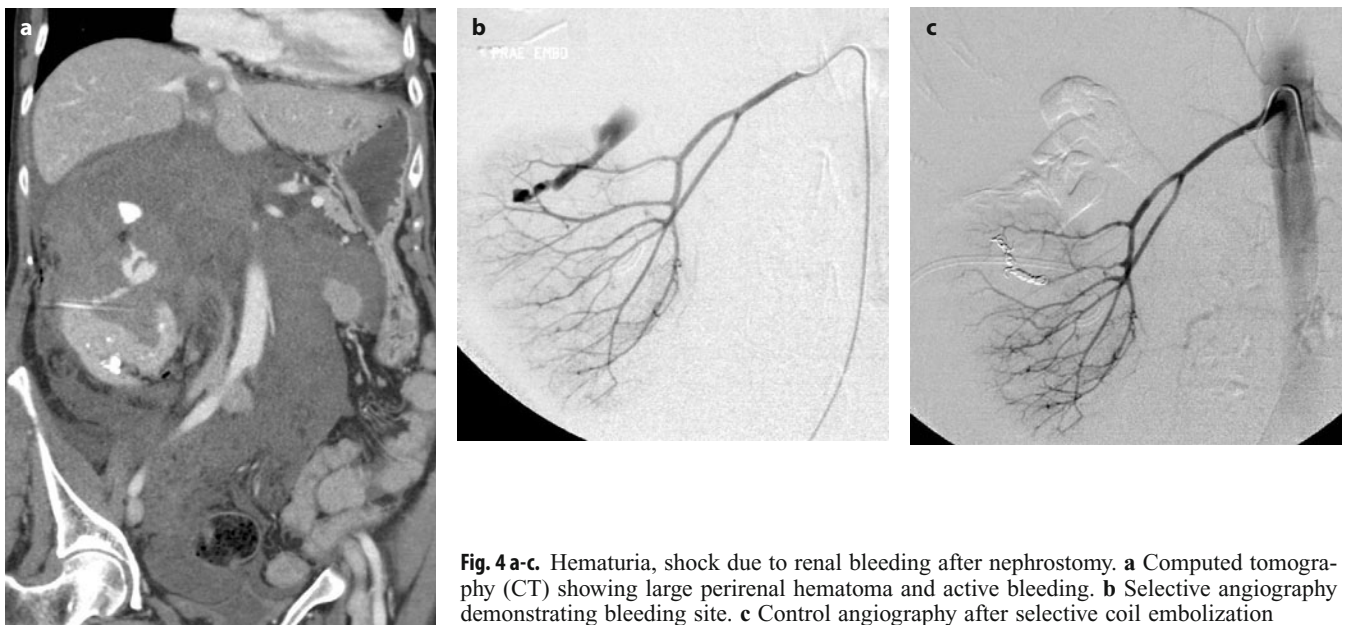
a-c. Hematuria, shock due to renal bleeding after nephrostomy. a Computed tomography (CT) showing large perirenal hematoma and active bleeding. b Selective angiography demonstrating bleeding site. c Control angiography after selective coil embolization
